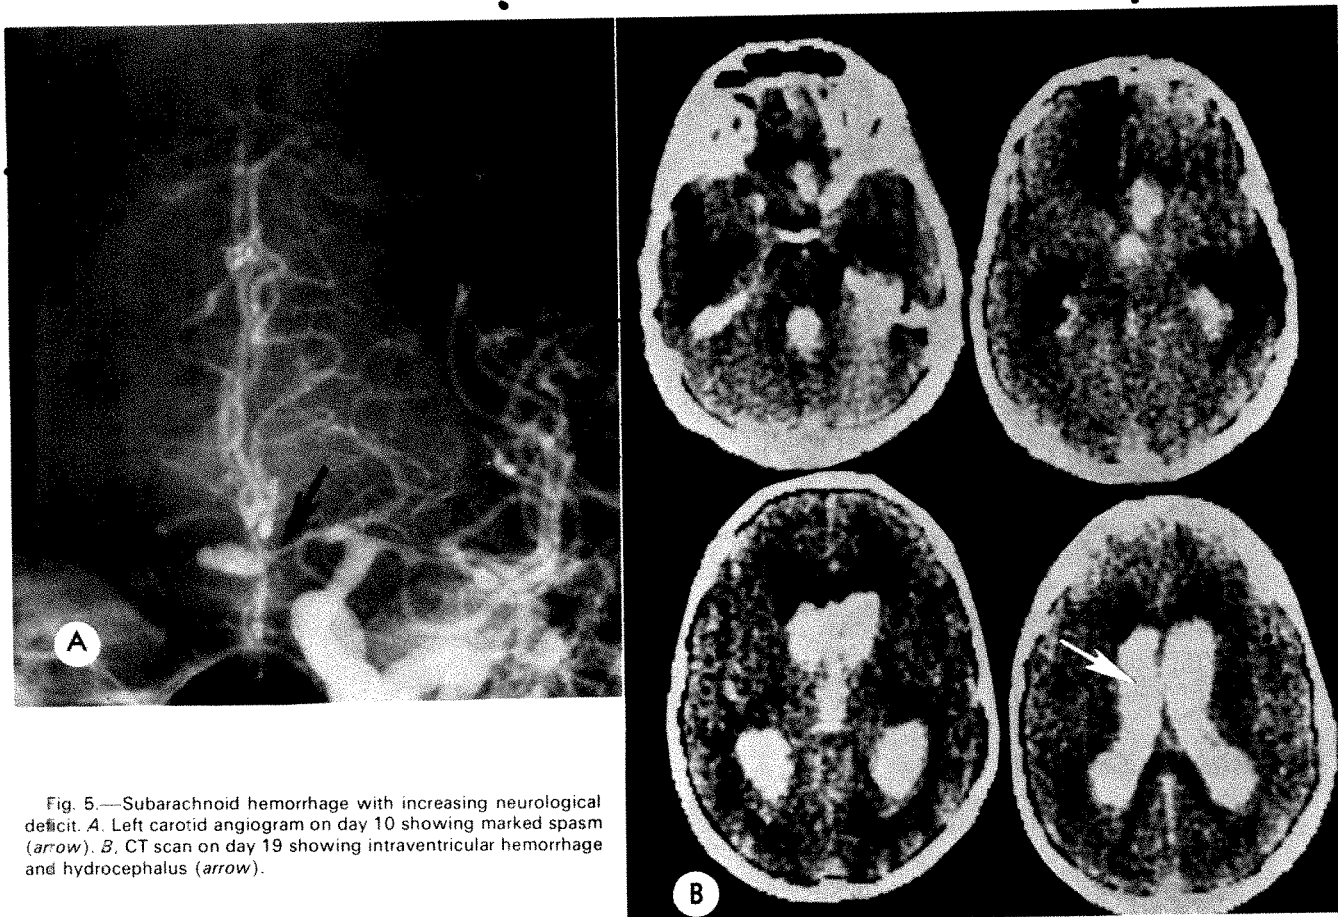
Subarachnoid hemorrhage with increasing neurological deficit. A. Left carotid angiogram on day 10 showing marked spasm (arrow). B. CT scan on day 19 showing intraventricular hemorrhage and hydrocephalus (arrow).
